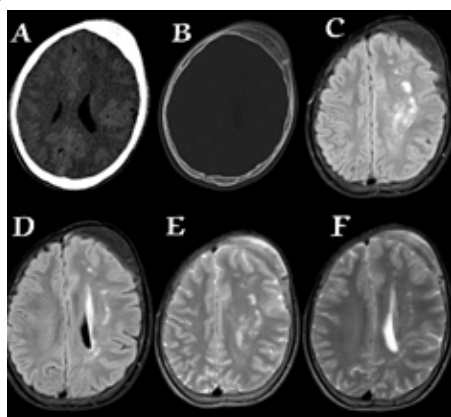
NCCT head brain window showing hypertrophy of left cerebral hemisphere with associated hypertrophy of frontal bone in bony window (Image A & B). MRI brain FLAIR & T2WI (image C, D & E, F) showing hemihypertrophy of left cerebral cortex with associated multiple punctate hyperintensities involving underlying deep white matter.
